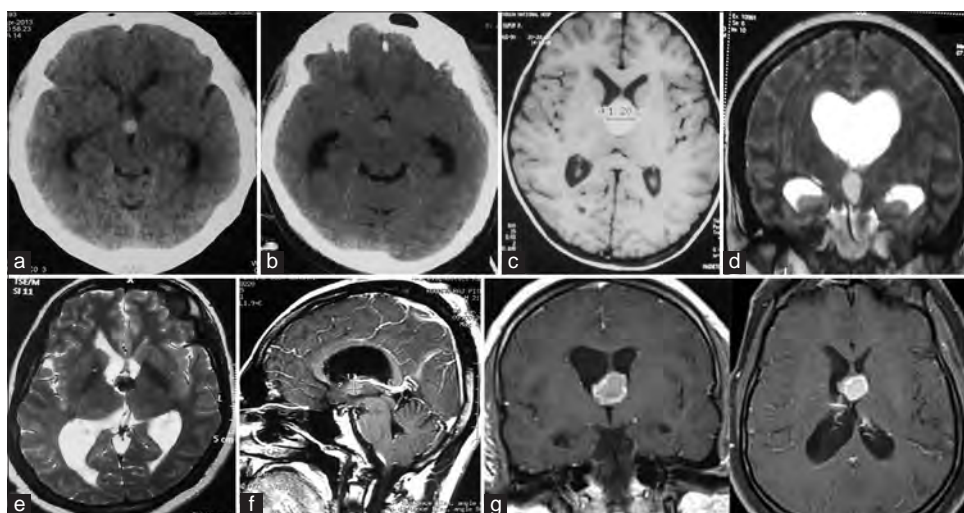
Normal imaging appearance of a colloid cyst. (a) Axial view of plain computed tomography (CT) showing hyperdense colloid cyst. (b) Plain CT scan axial view showing an isodense colloid cyst, which may produce a diagnostic dilemma. (c) T1-weighted axial view of magnetic resonance imaging (MRI) showing a mildly hyperintense colloid cyst. (d) T2-weighted coronal view of MRI showing a mildly hyperintense colloid cyst. (e) T2-weighted axial view of MRI showing a hypointense colloid cyst. (f) Contrast-enhanced T1-weighted sagittal view of MRI showing a non-enhancing colloid cyst. (g) Contrast-enhanced T1-weighted coronal and axial views of MRI showing mild peripheral enhancement of a hyperintense colloid cyst
